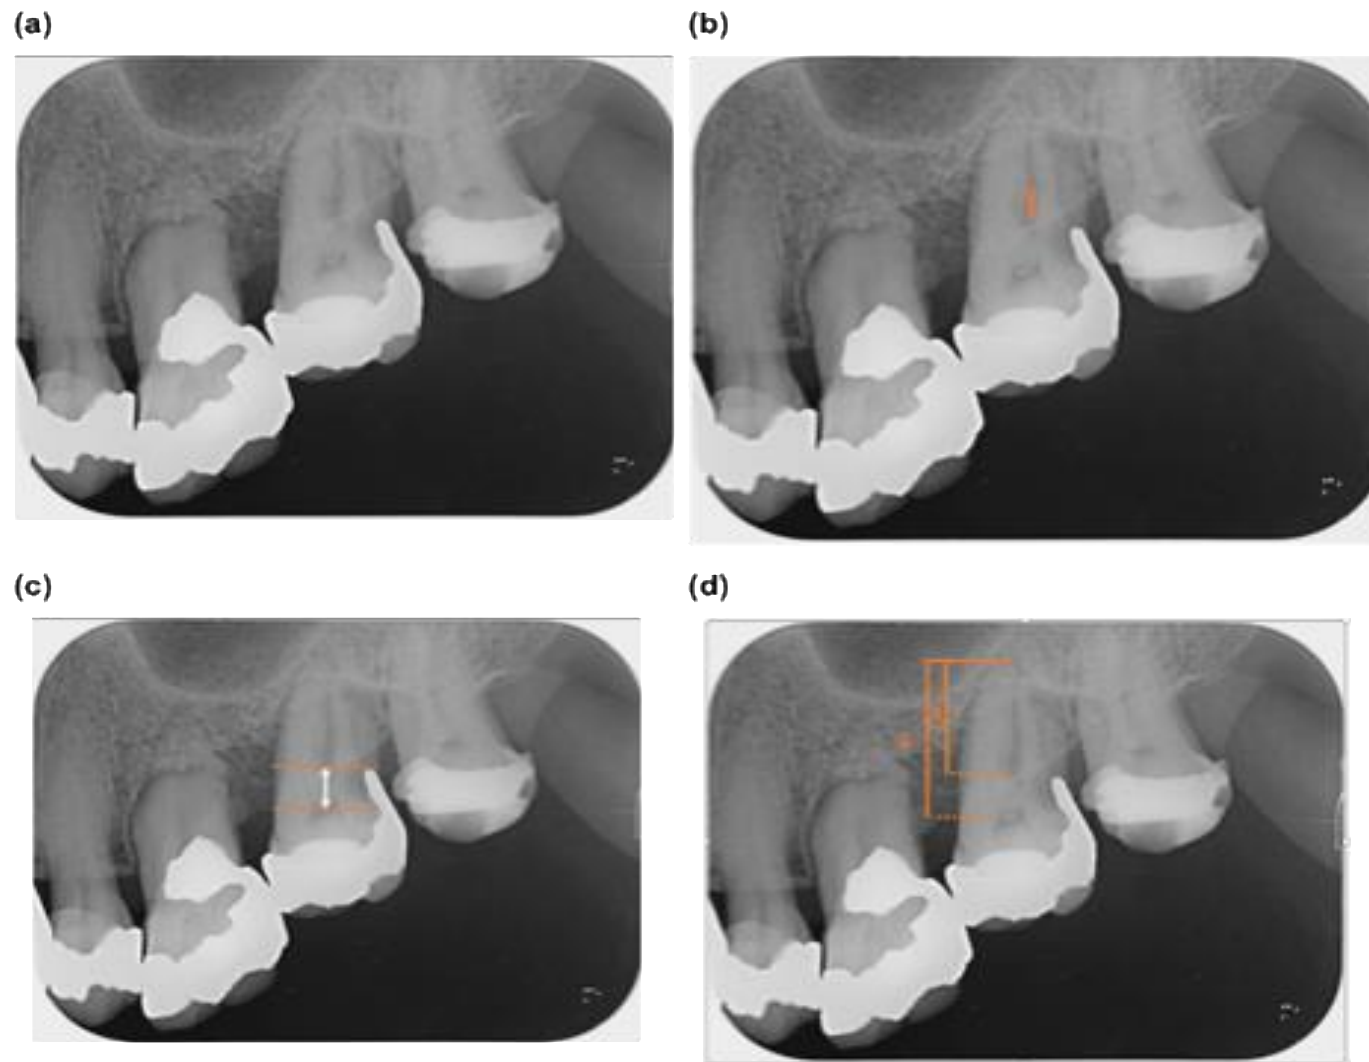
(a) Baseline radiograph. (b) Degree of separation. (c) Root trunk. (d) Coefficient of separation of the tooth 27.
